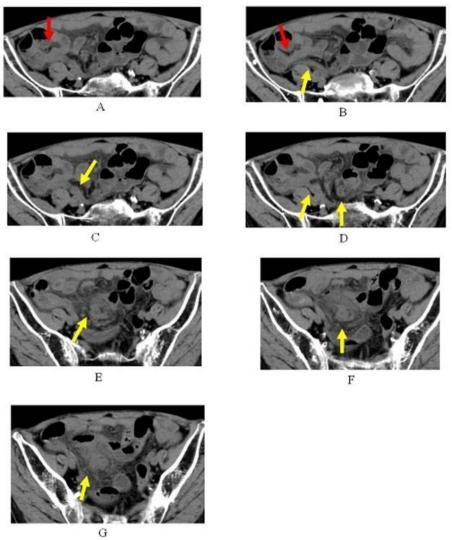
Axial images of non-enhanced CT depict the difficulty of finding the inlet of appendix to cecum because the both inlets of appendix and ileum are overlapped (A, B red arrow: ileum end). But appendix exists above the psoas muscle and iliac artery and iliac vein (B, C, yellow arrow). There exists a tubule with thick wall (E, F, G, yellow arrow). Note the infiltration to mesentery surrounding the tubule (F, G).
